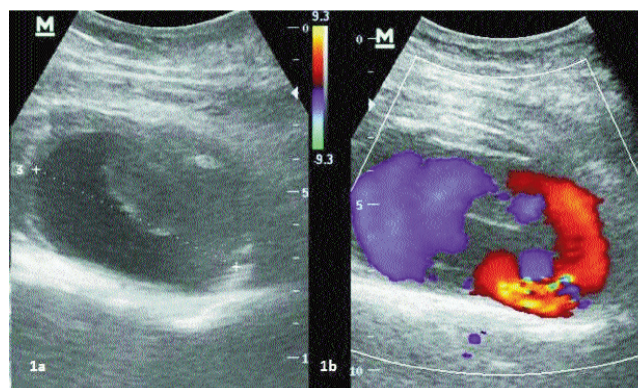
a) Left sided pseudoaneurysm, with partial thrombosis. b) Colour Flow Doppler Swirling flow of blood within the pseudoaneurysm.
